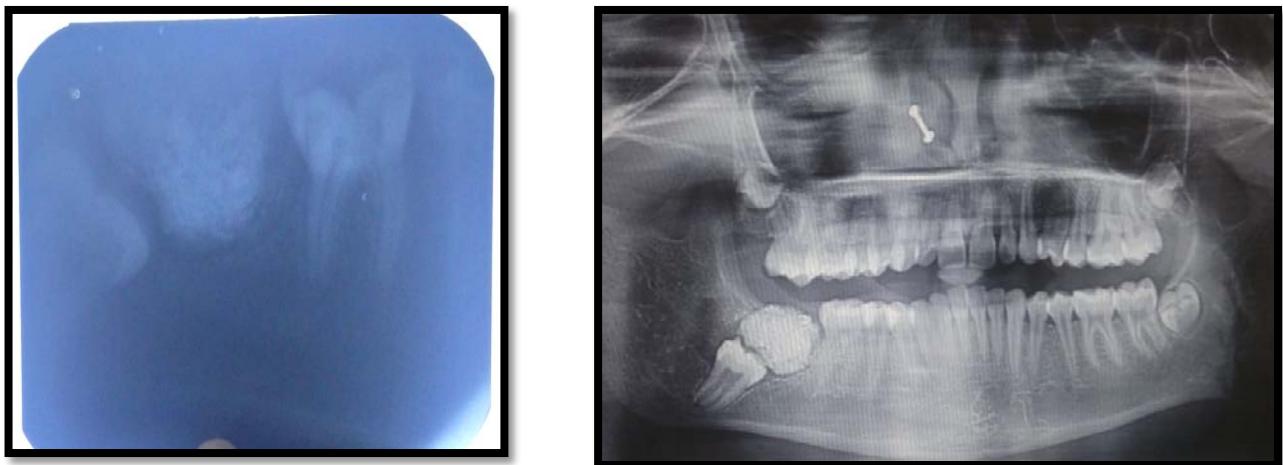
Preoperative IOPA & Orthopantomograph Revealing Radio Opaque Mass & Impacted Second Molar
